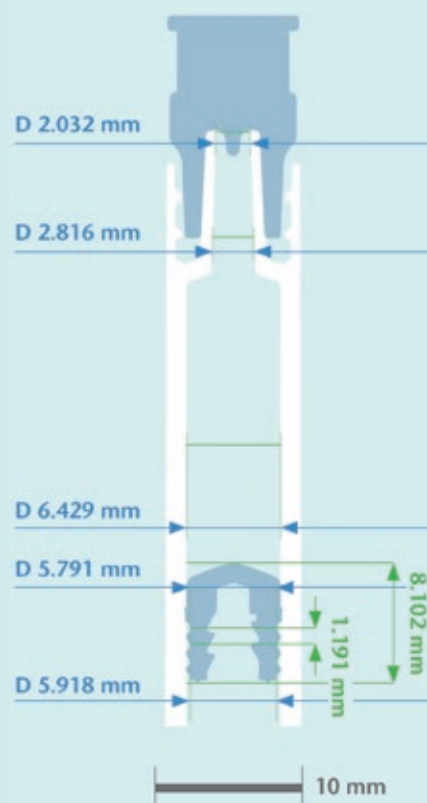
Computed tomography (CT) scan of identical COC syringe systems at different temperatures.
